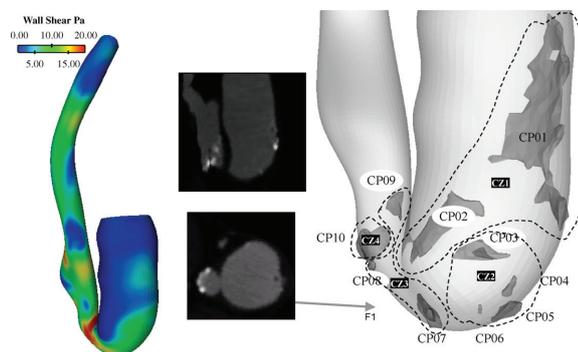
The wall shear stress distribution is shown on the left-hand side. From CT-scan angiography data (of which two sections are reported in the centre of the figure) the 3-D distribution of calcified regions has been obtained, and calcification plaques 'CP' have been distinguished by calcification zones 'CZ', as shown on the right-hand side [170].
